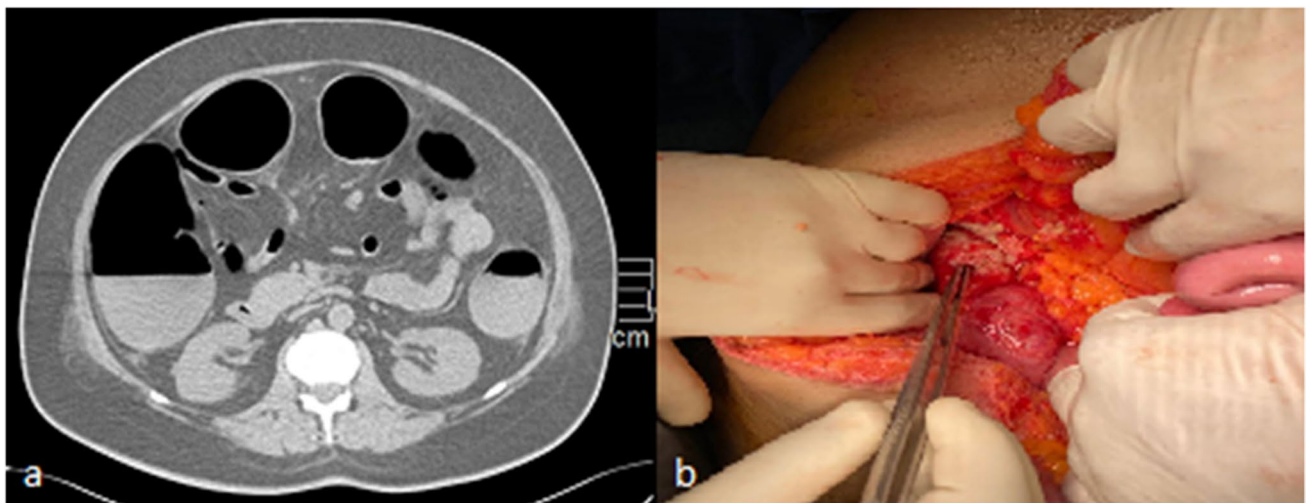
a Axial computed tomography abdomen with hypoenhancing ileal loop (vertical arrow) with intramural air (horizontal arrow). b Long segment ileal gangrene. c, d Microvascular thrombosis and submucosal necrosis with hemorrhage (arrow)
